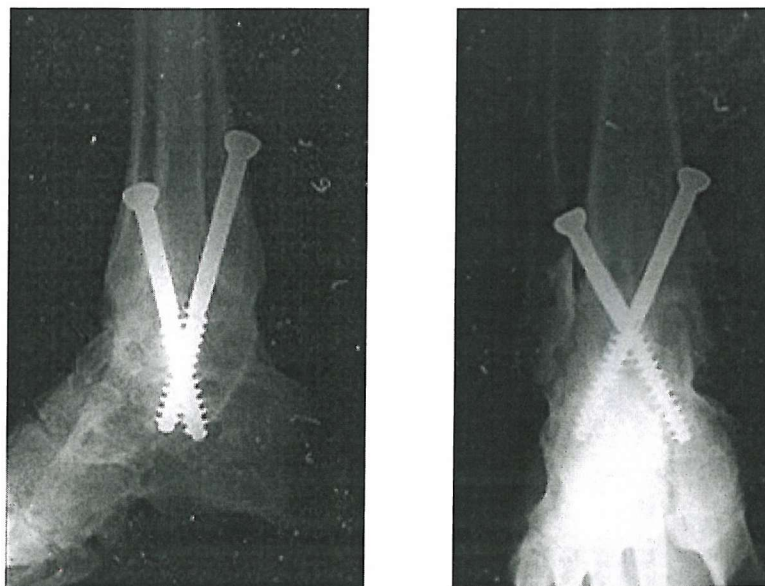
Lateral (left) and frontal (right) radiographs of a fused ankle with internal fixation. Two crossed screws were placed from proximal to distal using a percutaneous technique (Source: Lund University Hospital, Sweden).
